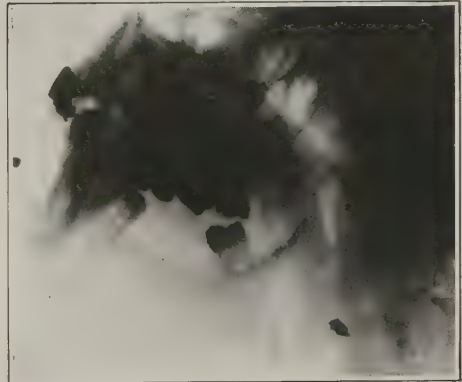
Radiograph showing missile and ossification in masseter muscle.
